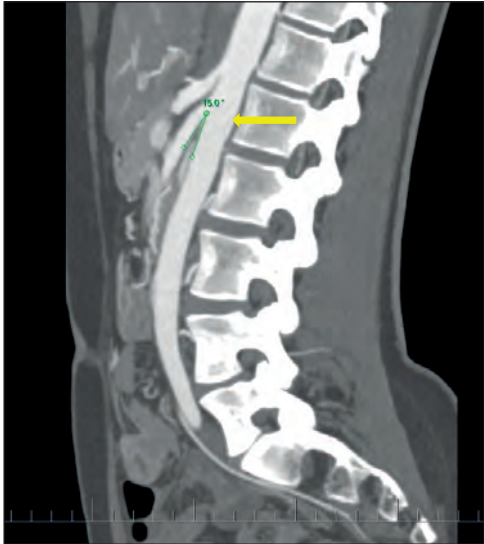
CT-venography findings of the left renal vein compression. Aortomesenteric angle = 15° (archive of the VÚSCH).
